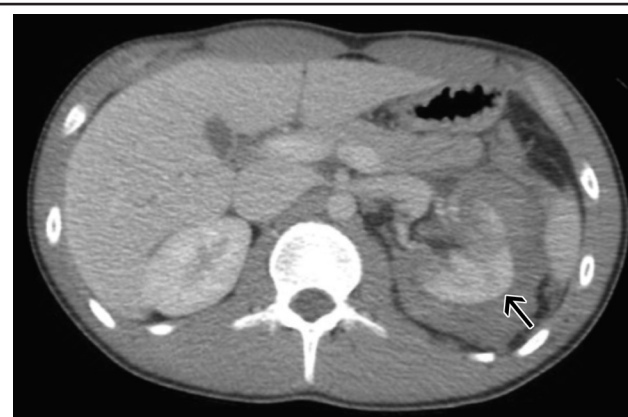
Arrival CT scan of a patient with a grade IV renal injury. The arrow indicates the area of hemorrhage.
